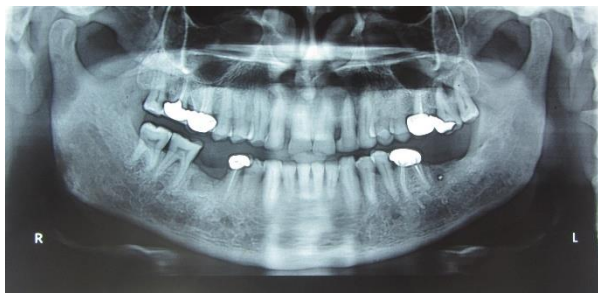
Panoramic radiograph showing a radiopaque metallic artifact on the right side of the alveolar ridge in the region of missing 37.
